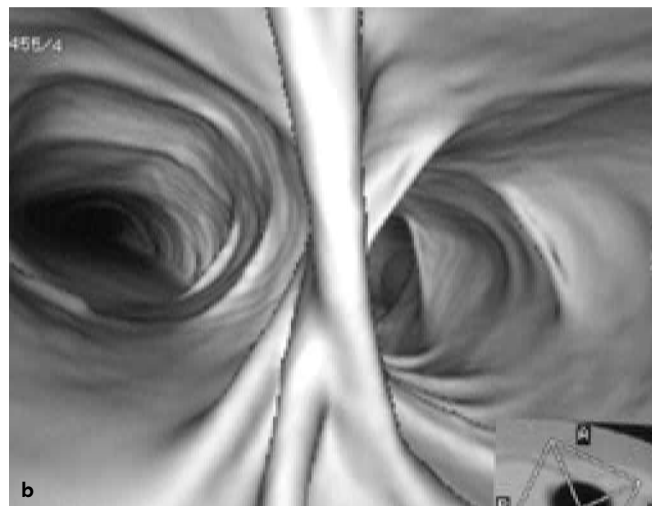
Virtual colonoscopy. Coronal reconstruction from a spiral computed tomography data set imaged on lung windows: (a) an air distended colon is visible. Arrow indicates the viewing direction of the endoscopic-like computer generated image at the splenic flexure; (b) the haustral folds are clearly visible.
